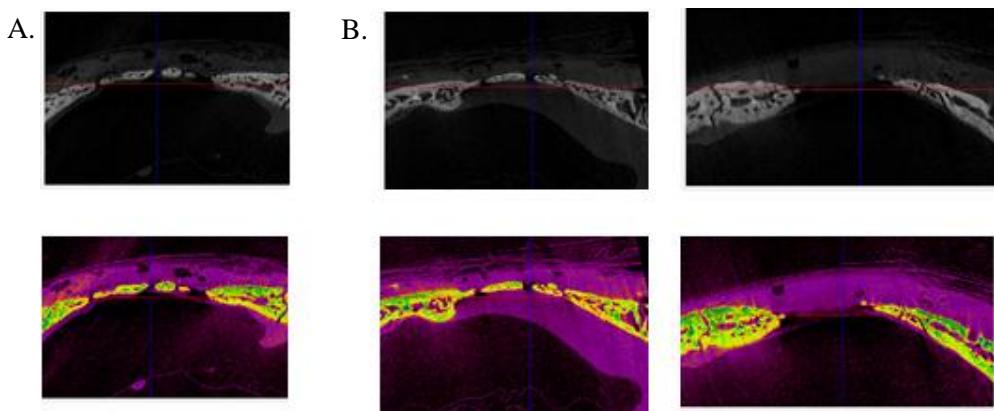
Micro CT images of collagen applied defects at 4 weeks. A. Collagen alone applied defect. B. Collagen+TAT-BMP-2 5 μ g applied defects.
